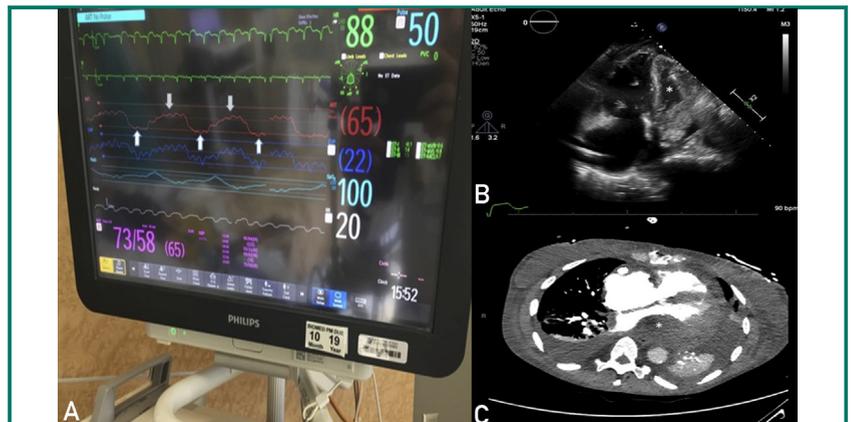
A, An arterial tracing showing no arterial pulsatility. The mean arterial pressure is 65 mm Hg (in red). There is an inspiratory decrease in the mean arterial pressure of greater than 10 mm Hg (upward arrows). The noninvasive blood pressure (in pink) captures this phenomenon nicely, measuring 73 mm Hg during the expiratory phase and 58 mm Hg during the inspiratory phase of the respiratory cycle. The mean noninvasive pressure is identical to the invasive mean arterial pressure. The central venous pressure is elevated, measuring 22 mm Hg (in blue). There is inappropriate relative bradycardia, and the heart rate is 88 beats/min (in green). B, Apical 4-chamber view showing right heart chamber enlargement and a small left ventricular cavity (asterisk). C, Computed tomography of the chest showing a small left heart chamber size and a compressive hematoma (asterisk) at the level of the atrioventricular junction.
